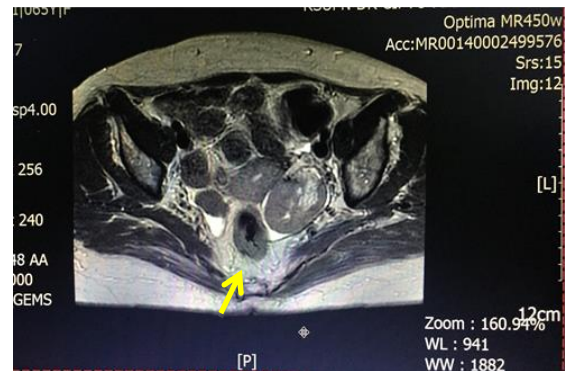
MRI finding: Fluid collection in the pelvic region (yellow arrow)
